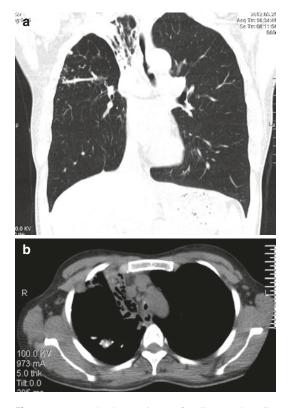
(a) Tracheal stenosis (see fine line on chest CT scan, lung window); (b) the longitudinal diaphragm window shows severe tracheal stenosis
